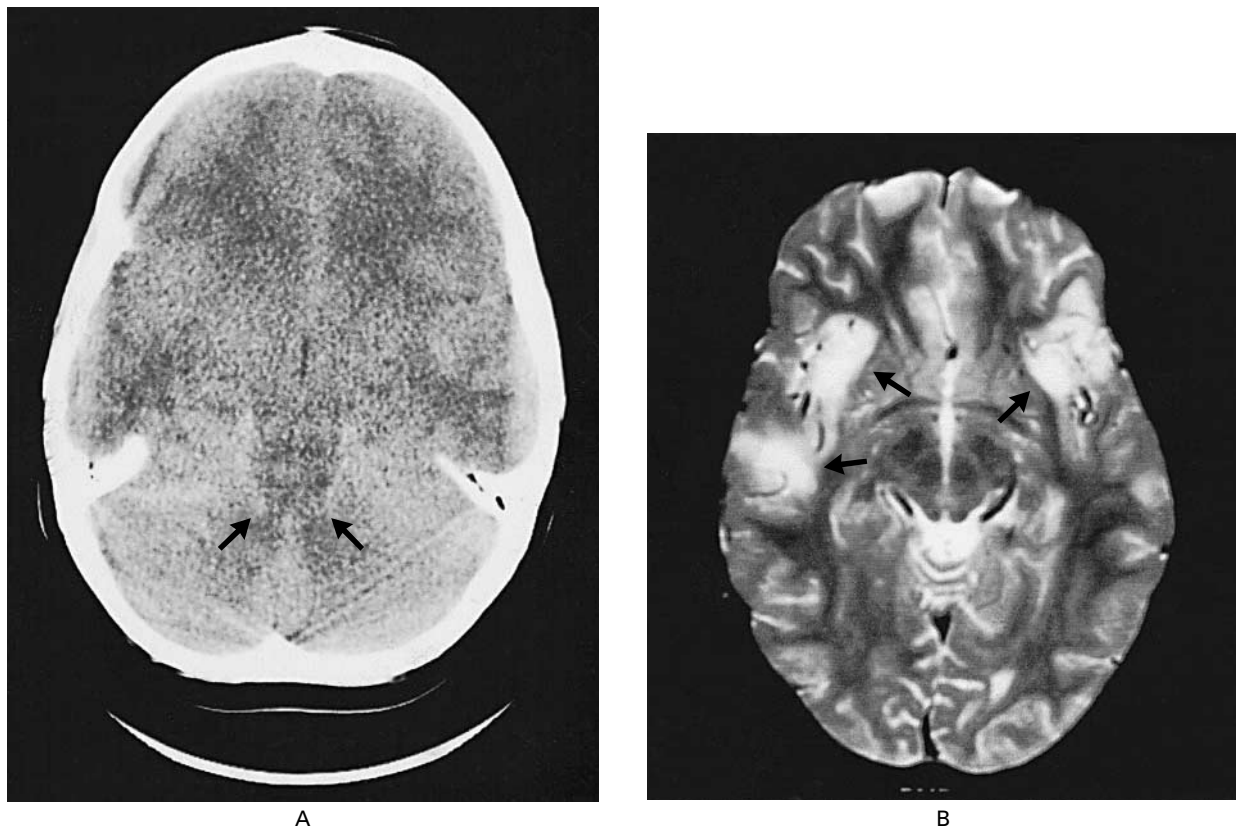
Radiographic Studies in Patients with Severe La Crosse Encephalitis.
